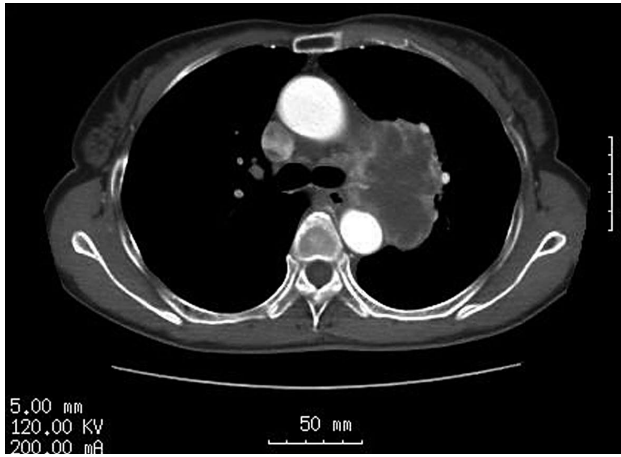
Computed tomography shows a mass shadow in the middle mediastinum.
